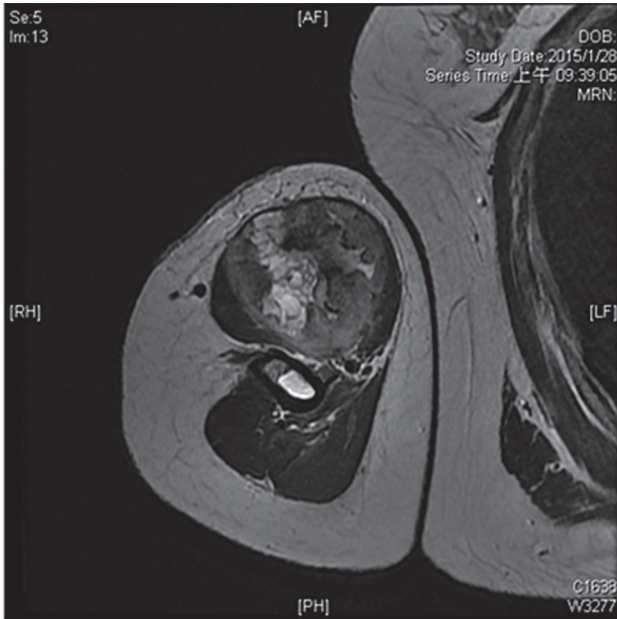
MRI showing a large intramuscular tumor within the right biceps with similar signals to muscles, internal septation, necrosis, and avid rim enhancement (no skin involvement).
